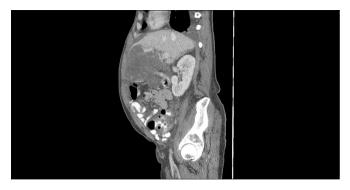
CT abdomen and pelvis. Mass-like process at level of celiac axis in right upper quadrant and slightly left of midline measures 9.2×11.2 cm. Probable mass-like process to left aspect of greater curvature of the stomach extending into overlying peritoneum, surrounding the stomach and part of the spleen, measuring 11.5×15.5 cm. Overall, size of mass is smaller than in previous scans.
